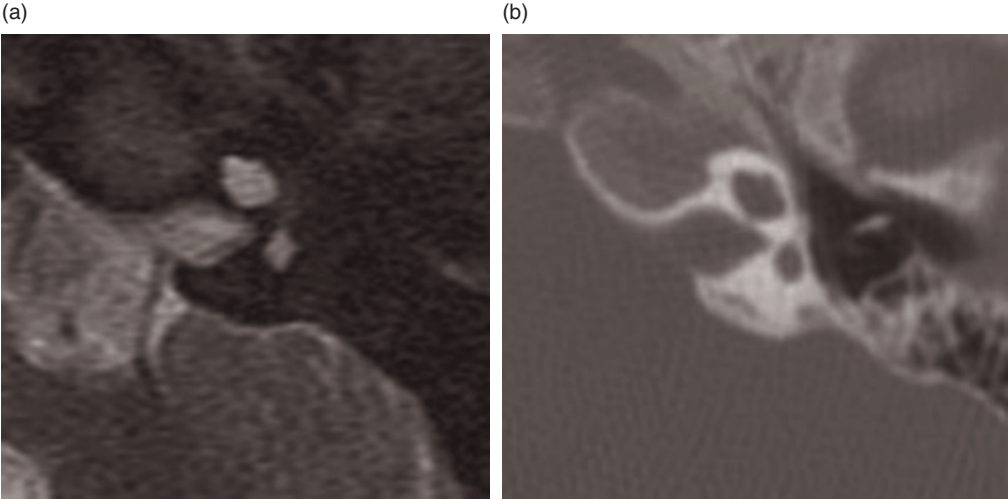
‘Cochleovestibular hypoplasia’: T2-weighted MR (a) and CT (b) axial images.
